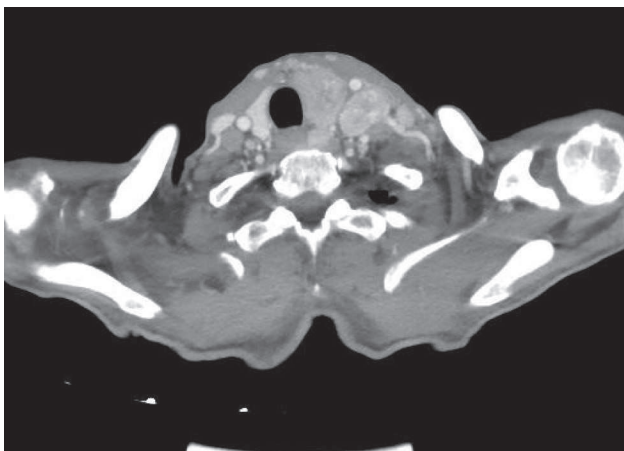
Computed tomography image (axial view) shows enlargement of the left thyroid lobe, where a solitary nodule with a heterogeneous contrast enhancement is detected.
